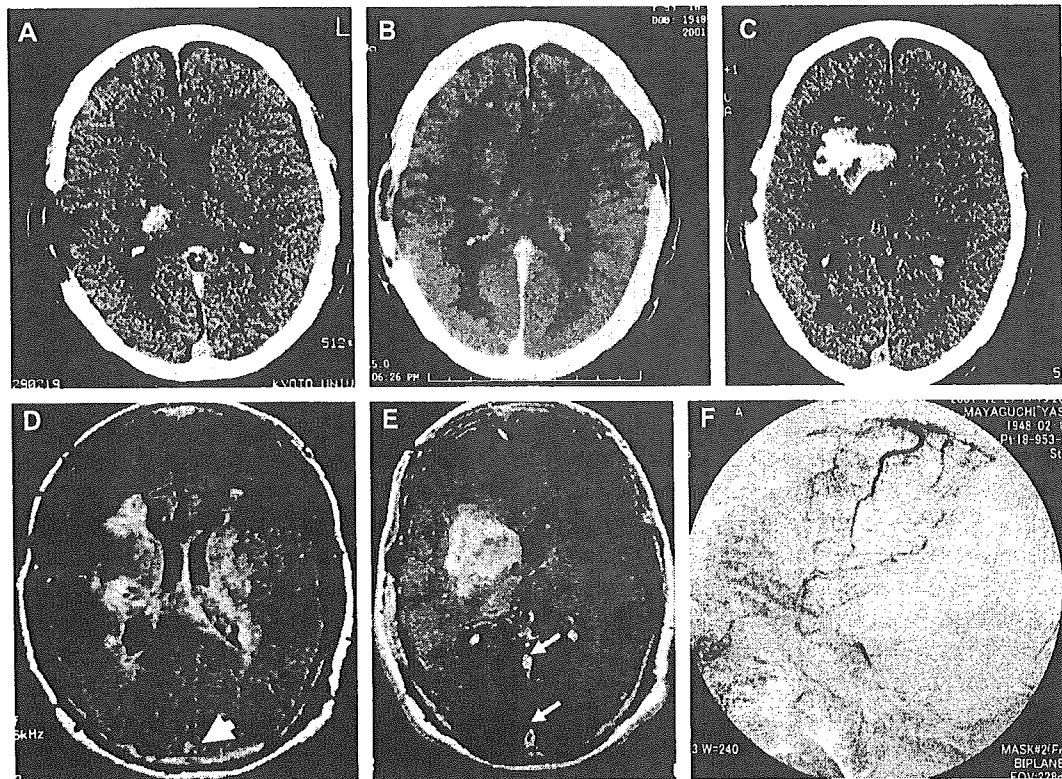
Axial CT on December 21, 2001 (A), on December 27 (B), and on January 4, 2002 (C), demonstrating progression of intracerebral hemorrhages with peripheral edema. D: Axial fluid-attenuated inversion recovery image of MRI indicating thrombus within the superior sagittal sinus (arrowhead). E: Axial T1-weighted image with contrast enhancement showing filling defect of contrast medium within the superior sagittal sinus and the straight sinus (arrows). F: Left external carotid angiogram demonstrating sinus thrombosis including the superior sagittal sinus, the transverse sinus, and the straight sinus.
